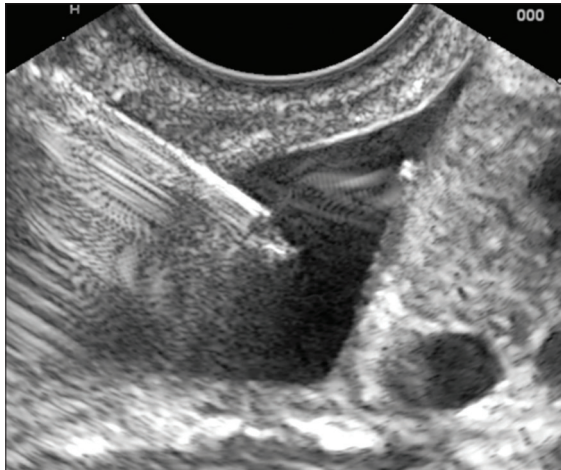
Endoscopic ultrasound-guided paracentesis of minimal ascites through the stomach
